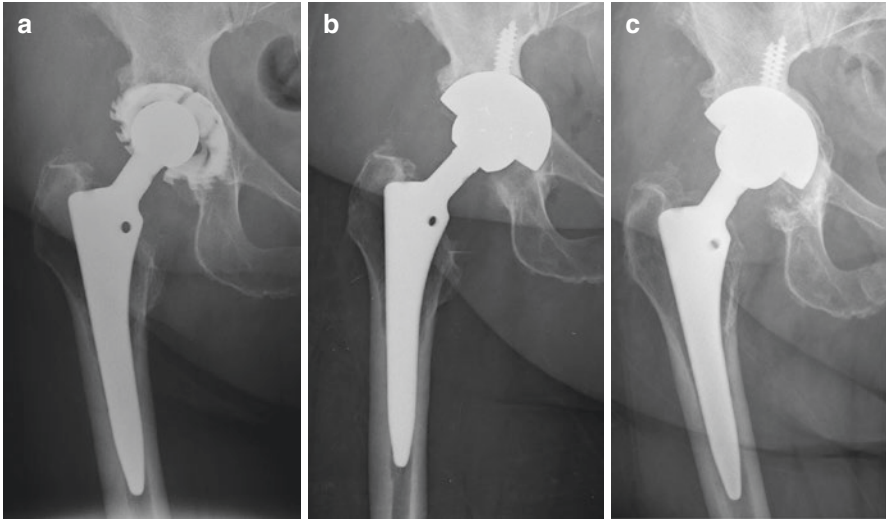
(a) Preoperative radiograph shows a loosened cementless cup. (b) A porous tantalum cup was used in revision surgery. (c) Two years later medial wall remodelling was observed and the clinical outcome is good
